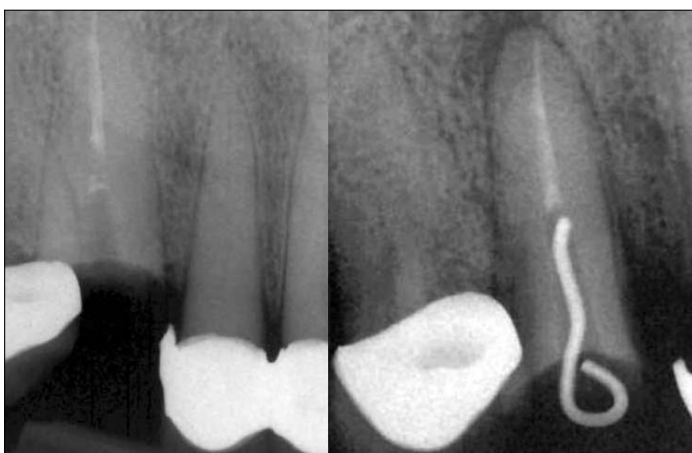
Radiographs depicting before and after. Note 4 mm of apical radiolucency immediately after eruption.
